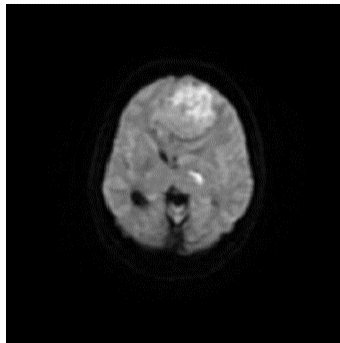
Original DWI sample image.
